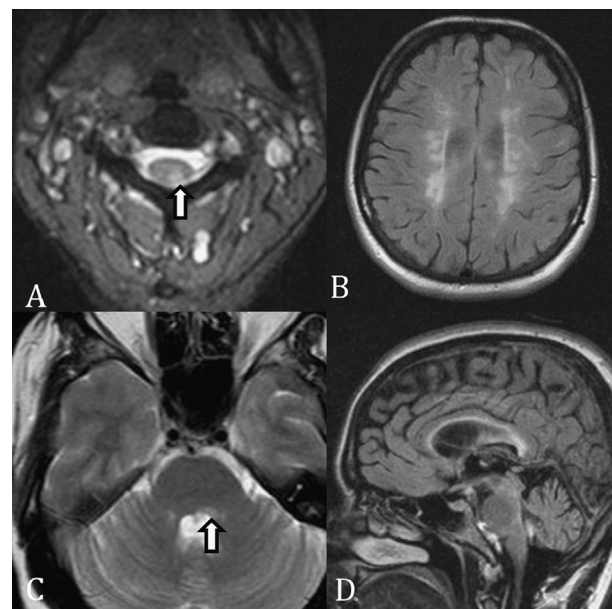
A patient (case 3, Table 1) with SLE and MS coexistence. MRI of the spine with T2 sequence in axial plane reveals a hyperintense lesion at the left posterolateral portion of the cervical spinal cord (A, arrow). MRI of the brain with FLAIR sequence in axial (B) and sagittal (D) planes and T2 sequence in axial plane (C), show multiple, hyperintense lesions at the periventricular and subcortical white matter and also at the corona radiata (B), the left posterior part of the upper pons (C, arrow) and the corpus callosum (D). The imaging characteristics and anatomic distribution of the lesions indicate demyelinating disease with dissemination in space, typical of MS.
